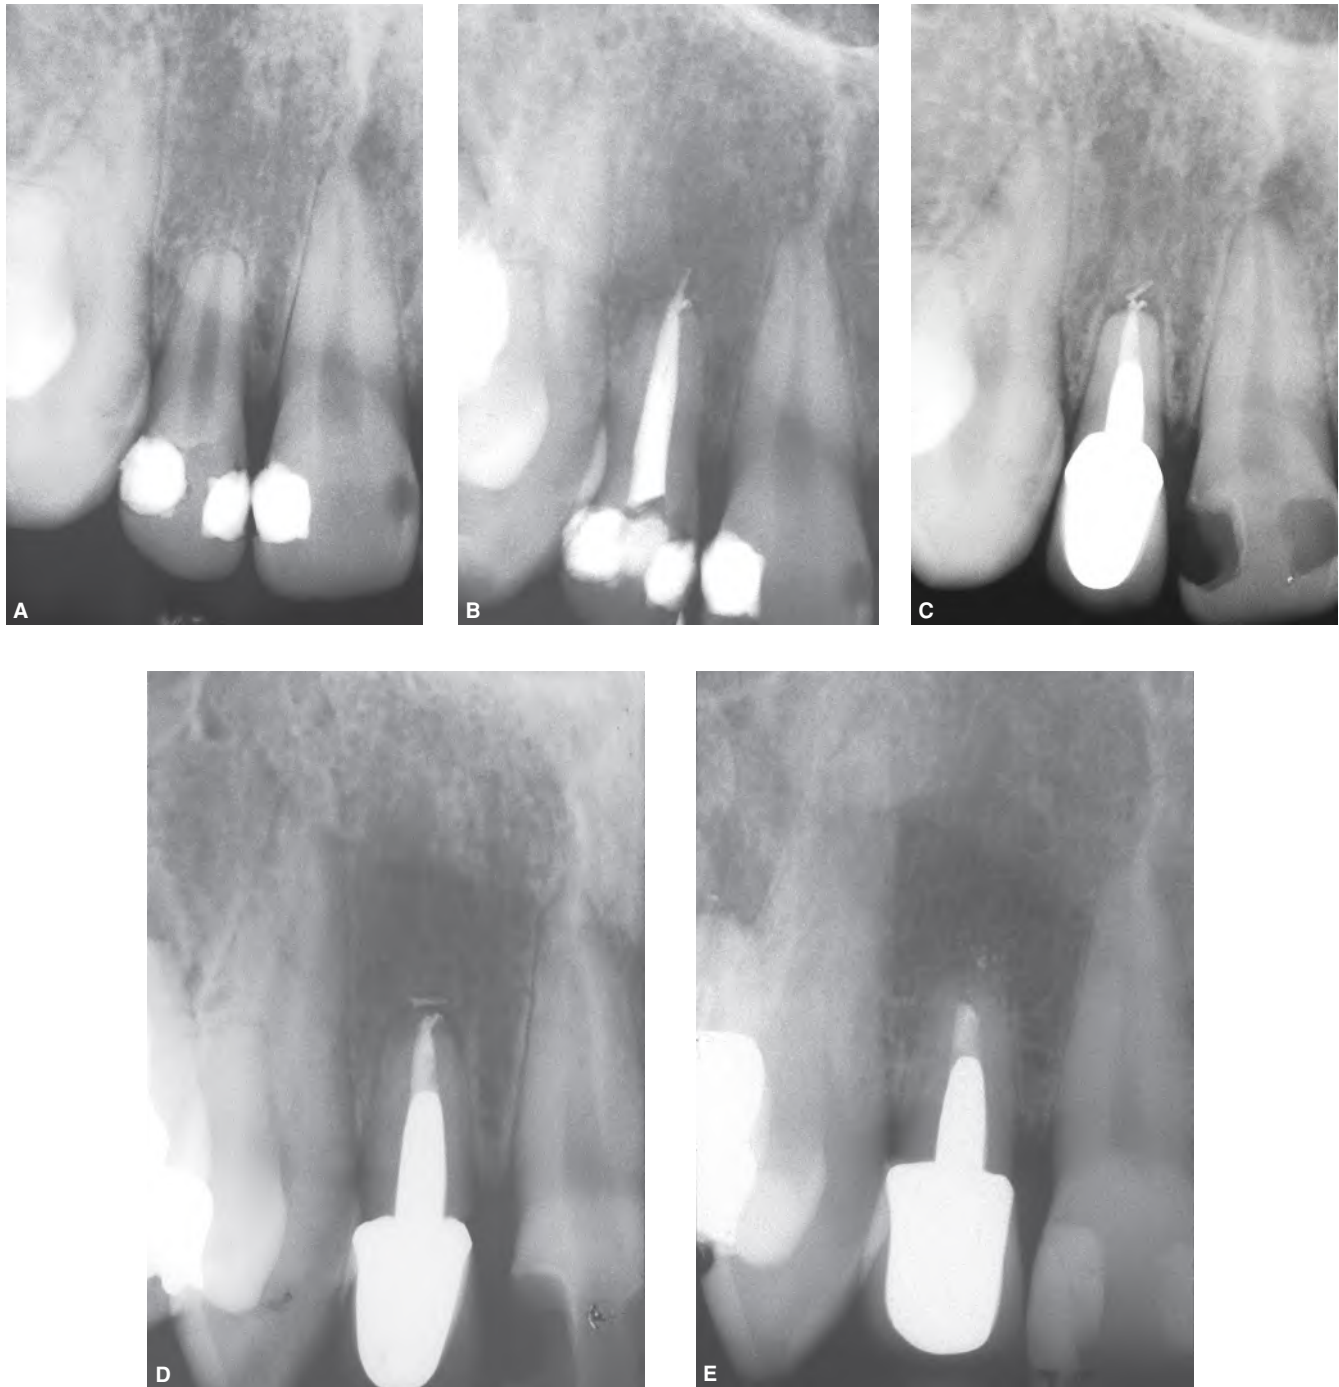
Endodontic treatment in a maxillary right lateral incisor with a resorbed root. A. Preoperative radiograph. B. Postoperative radiograph. The tip of the cone slid 2–3 mm beyond the apex, probably because the “tug-back” of the cone was not at the apical area. C. One year later, the excess material appears to be sectioned at the apical foramen. D. Two-year postoperative radiograph. The tip of the cone lies horizontally over the root apex. E. 34-year recall confirmed that an overfilling in a three-dimensionally obturated root canal was NOT necessarily an indication for surgery or cause for endodontic failure.
